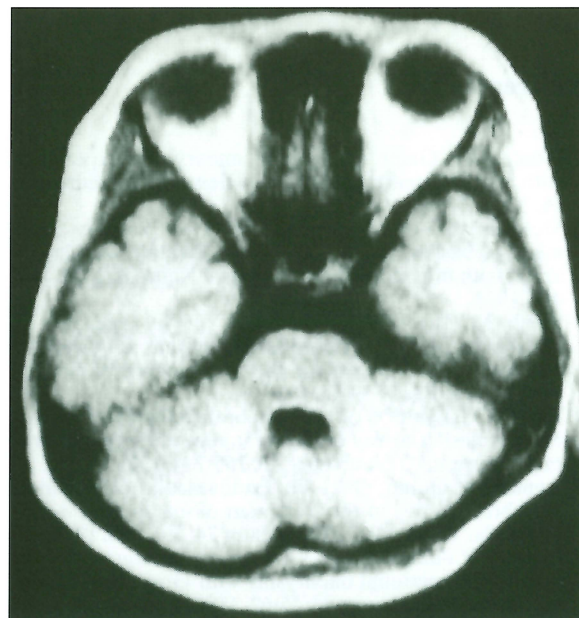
Case 2. MRI (T1 weighted) six month follow-up shows the mass in the front has disappeared and the brain stem has recovered its normal shape.
